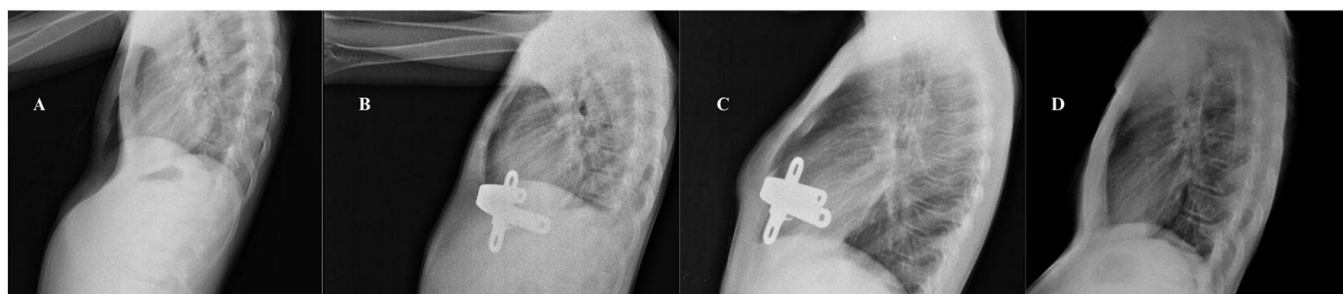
The patient's lateral chest X-ray before the Nuss procedure (A). The patient's lateral chest X-ray after the Nuss procedure (B). The patient's lateral chest X-ray seven months after the Nuss procedure, before bar removal due to the development of pectus carinatum (C). The patient's lateral chest X-ray four years after bar removal (55th month) due to the development of pectus carinatum (D).
